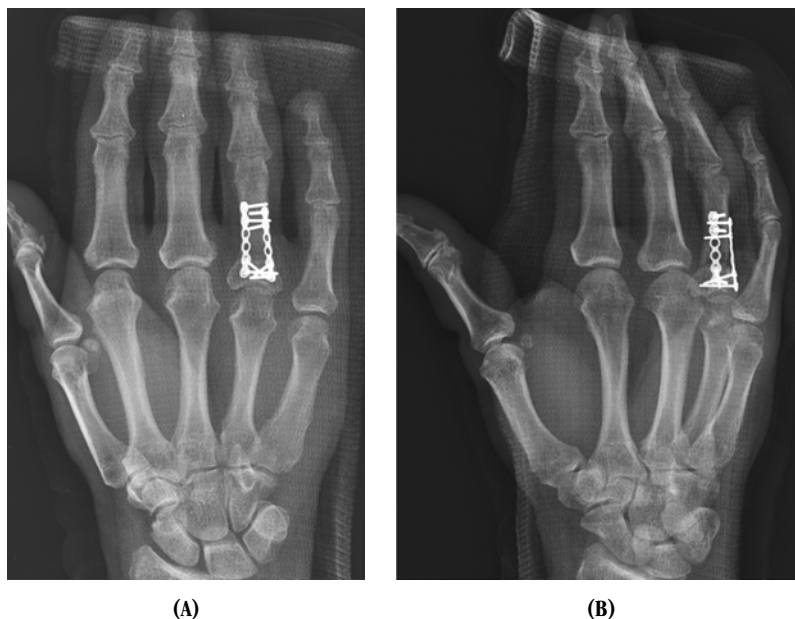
Post-operative (A) AP and (B) oblique radiographs of ring finger with hardware in place and showing good alignment.
